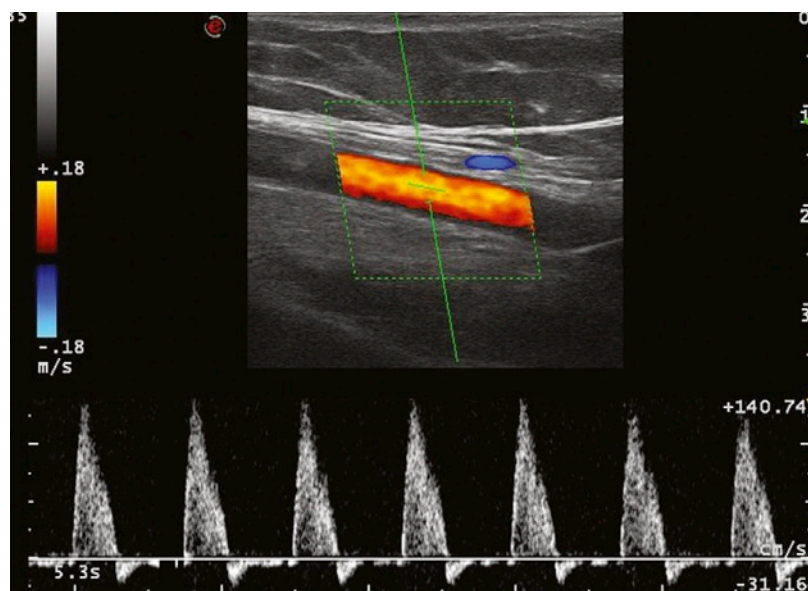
Duplex sonography shows a normal axillary artery in a longitudinal view. The Doppler curves show a rapid systolic increase of flow velocity and postsystolic retrograde flow.
